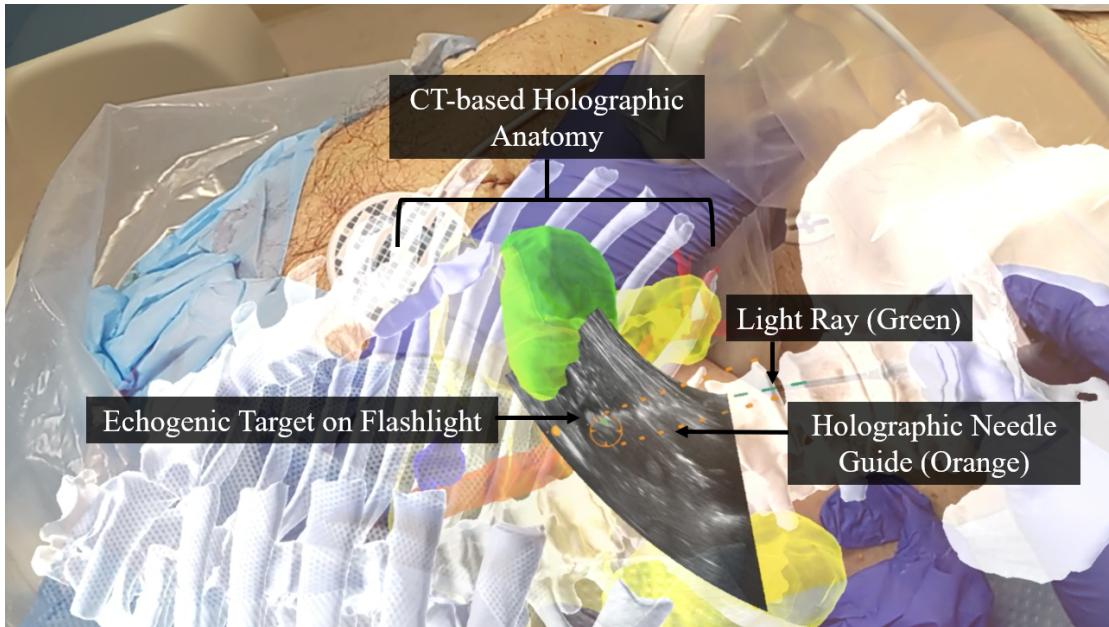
Depiction of three main registered projections visible to the operator when using the AR platform. 1 3D anatomical models, such as bone (white, liver (green) and kidney (yellow). 2 Ultrasound Flashlight: projected coaxially with echogenic target. 3 Holographic Light Ray in dark green. An additional needle guide feature is displayed in orange.
